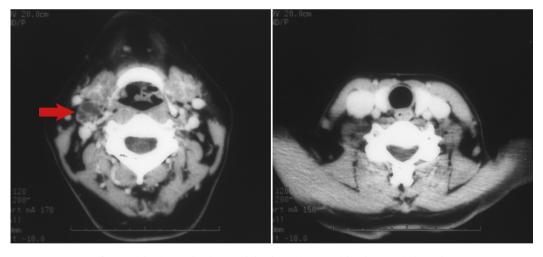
Axial CT image showing a multilocular cystic mass with a clear margin (arrow).
